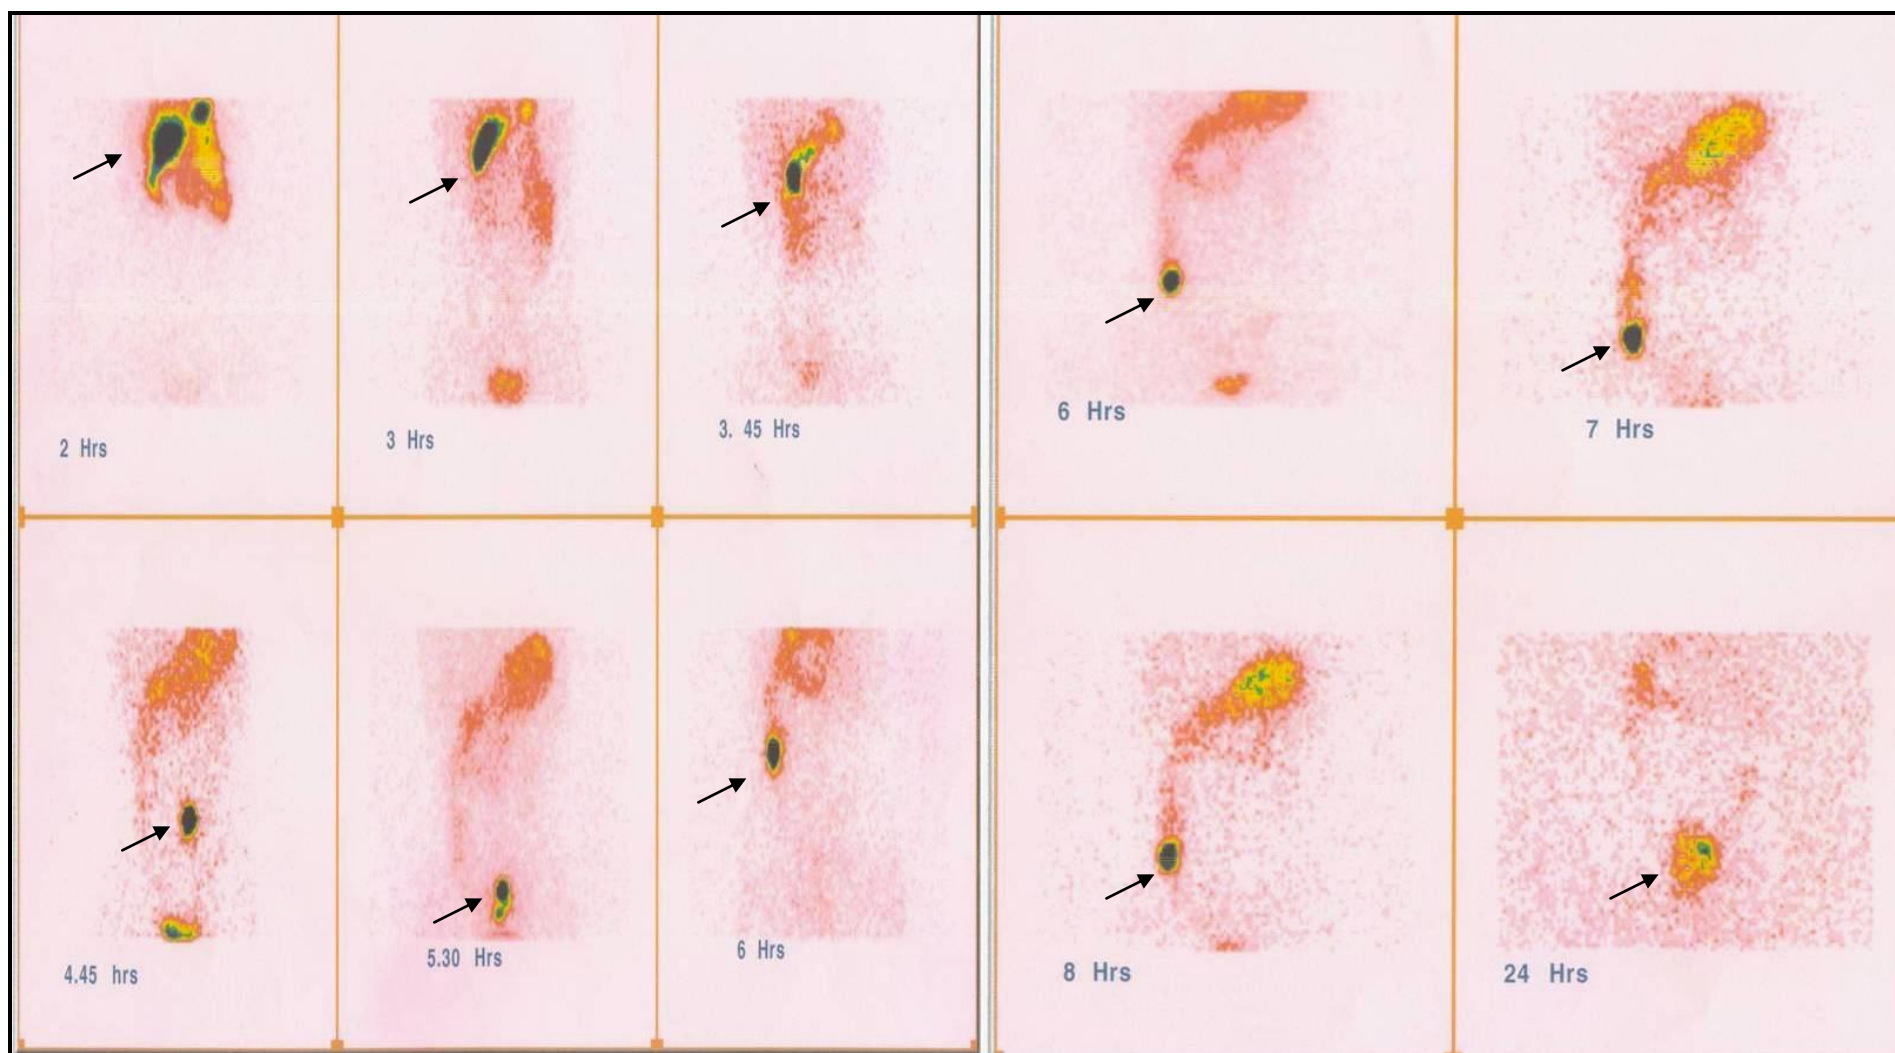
Gamma scintigraphic images showing GI and colonic transit of CP based formulation ICP5EL10 in human subject. Arrow indicates tablet position.
